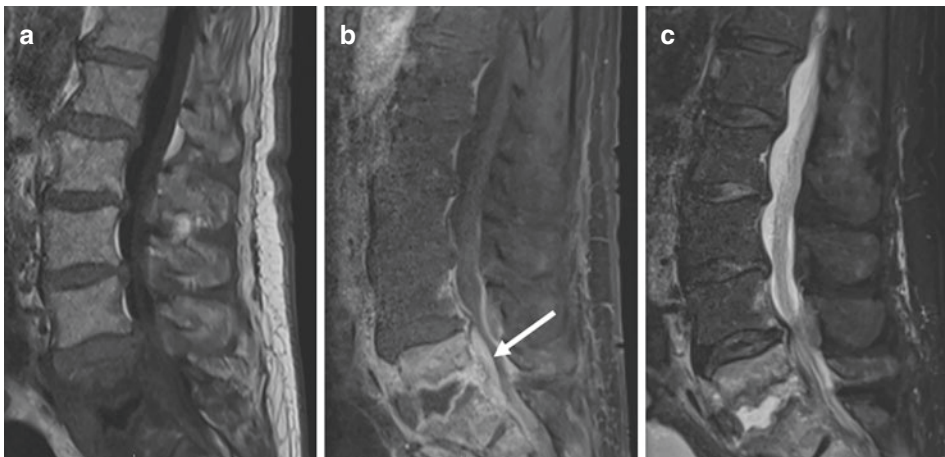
Osteomyelitis/discitis of the lumbar spine. (a) Sagittal T1-weighted MRI shows homogenous hypointense signal in the L5 and S1 vertebral bodies. (b) Sagittal T1-weighted MRI with contrast and fat saturation shows homogenous enhancement of the L5 and S1
